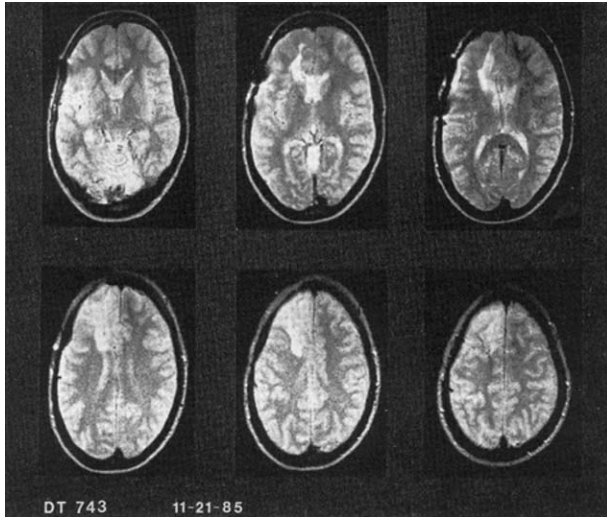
MRI scan of DT as an adult (26 years after lesion) showing left mesial and polar prefrontal damage.
